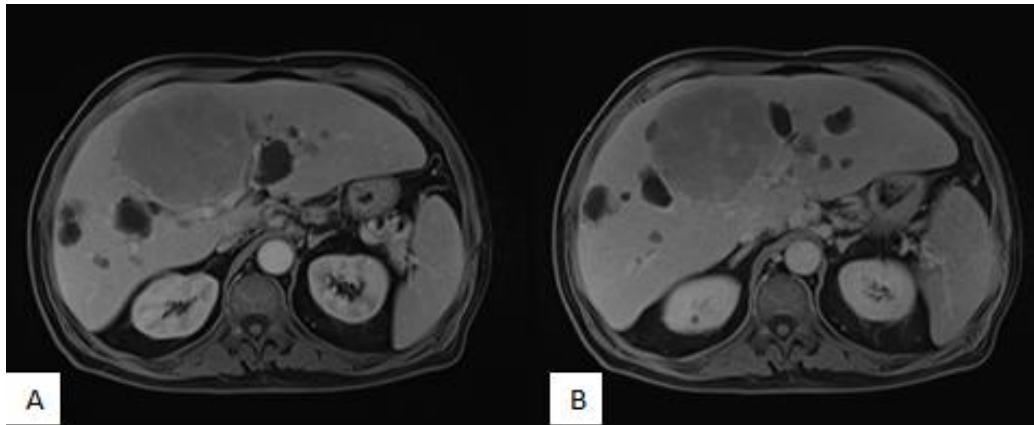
Hepatic MRI in T1 sequences with gadolinium at early (A) and late (B) post-contrast phases showing the Dot-Sign and late-phase enhancement of the mass
